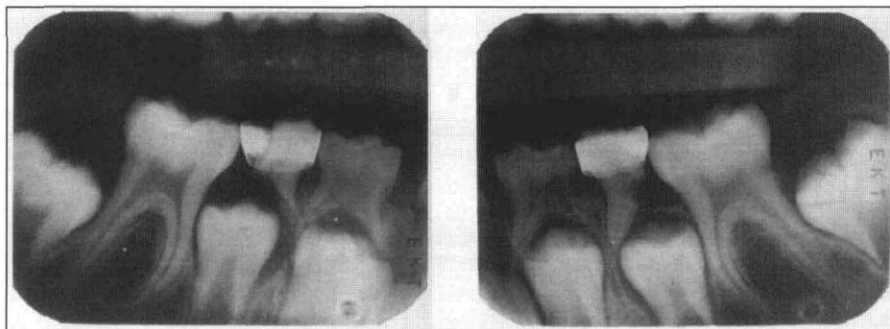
Bite-wing radiographs 2 years post treatment. Note the favorable position of first permanent molars.
